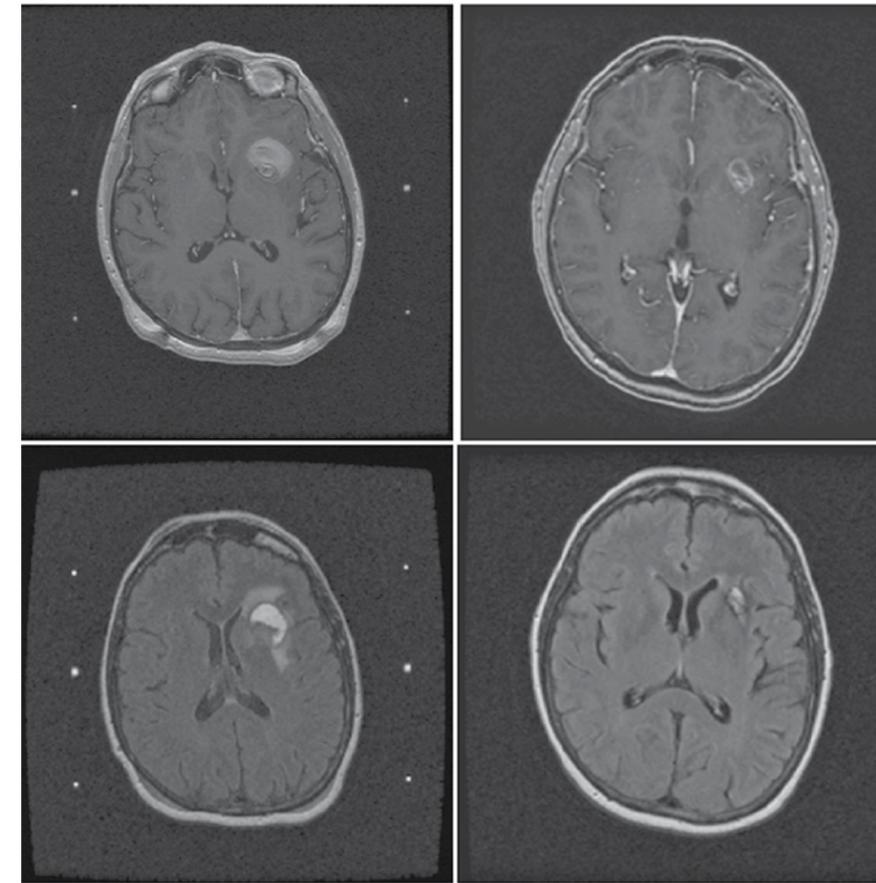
A 58-year-old patient with a large melanoma brain metastasis (left column) received Gamma Knife stereotactic radiosurgery (SRS) to a dose of 18 Gy. Repeat magnetic resonance imaging three months after SRS showed tumor shrinkage and decreased edema (right column). The tumor continued to shrink, and there was no evidence of intracranial recurrence at the time of death (from progressive systemic disease) more than 12 months after SRS.
